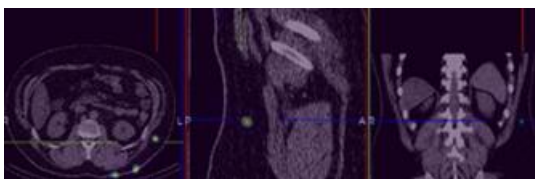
Hyperfixative focus in the left lumbar region with the appearance of a nodular structure identified on SPECT/CT. Additional activity is also seen at the injection sites around the scar.
